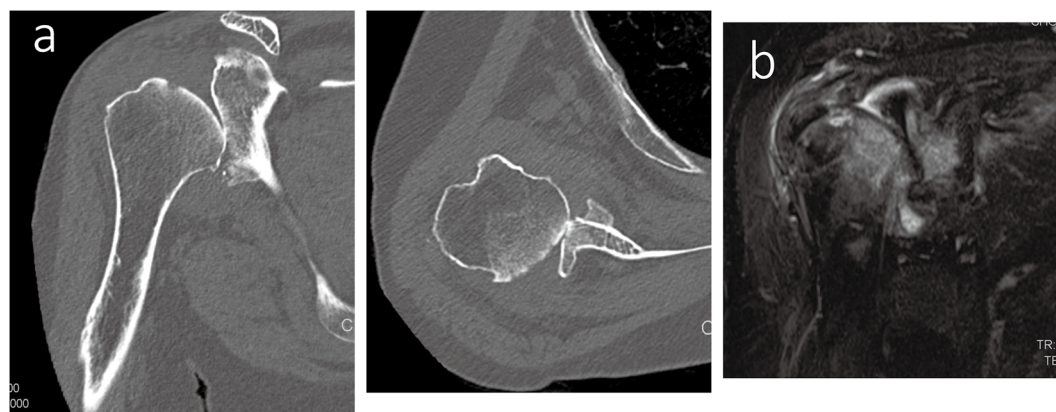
A preoperative image of case 1. (a) Plain computed tomography (CT) image of right shoulder joint, (b) Magnetic resonance imaging (MRI) Short Tau Inversion Recovery (STIR).
